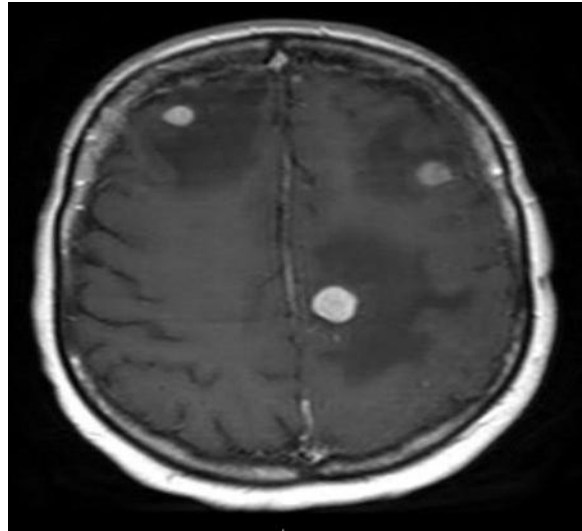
A CT radiograph depicting 3 brain metastasis (3 small white circles)(Arnaout *et al.*, 2024; Tabouret *et al.*, 2012)
